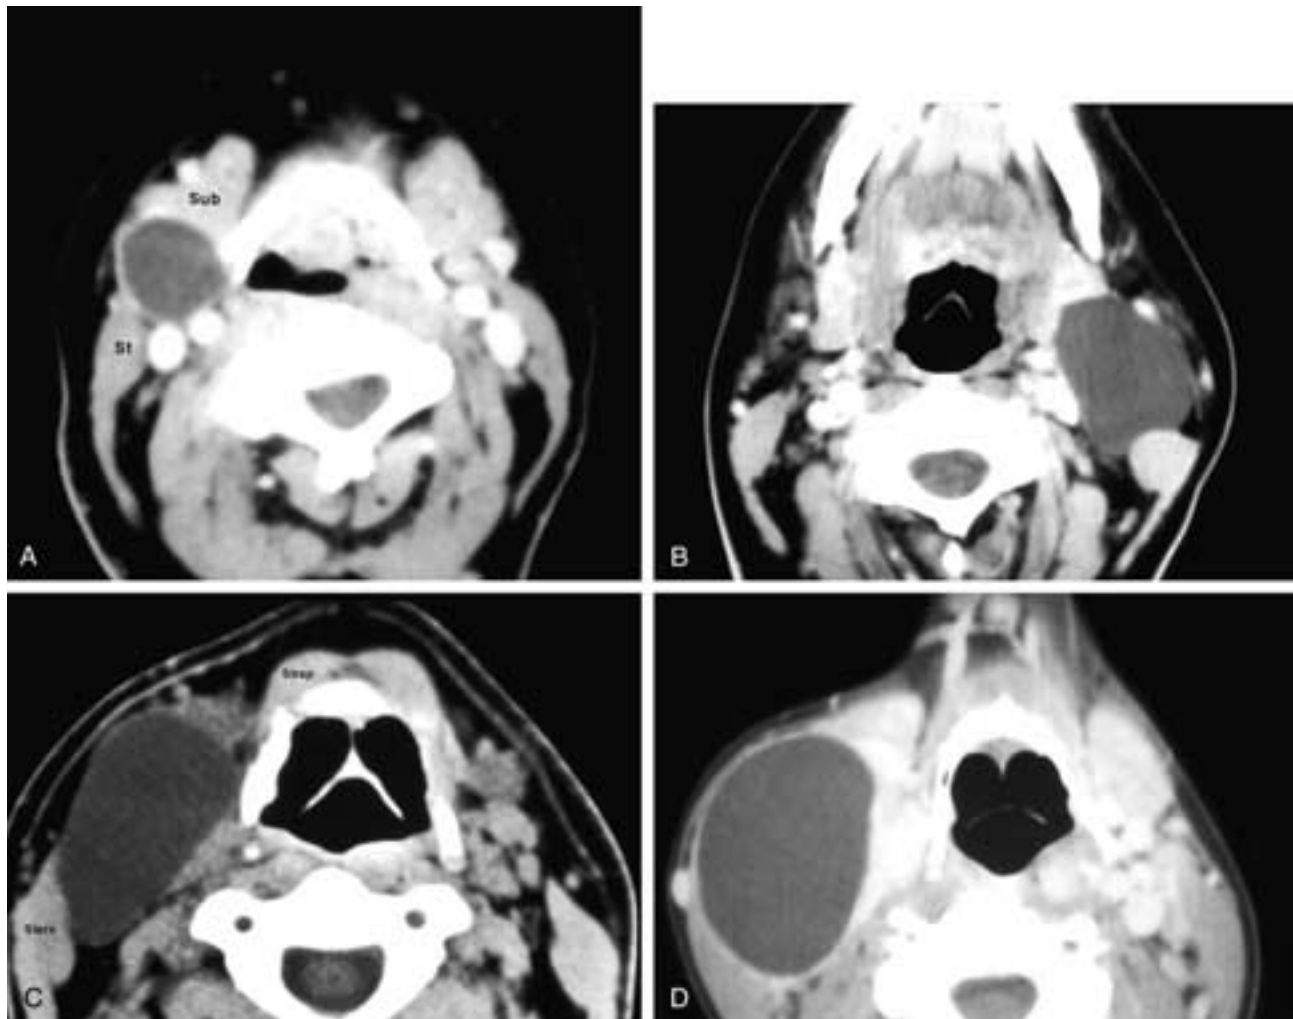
A, Axial contrast-enhanced CT scan shows a uniformly thin-walled right neck cyst positioned lateral to the carotid sheath structures, behind the right submandibular gland (*Sub*), and along the anterior border of the sternocleidomastoid muscle (*St*). This second branchial cleft cyst was located just caudal to the angle of the mandible. B, Axial contrast-enhanced CT scan shows a left neck cyst just behind the submandibular gland, lateral to the carotid sheath structures, along the anterior border of the sternocleidomastoid muscle, at or just caudal to the level of the angle of the mandible. This was a first branchial cleft cyst. C, Axial CT scan shows a large right neck cyst behind the submandibular gland, lateral to the carotid sheath structures, and just caudal to the level of the angle of the mandible. As this second branchial cleft cyst enlarges, the unseen superficial layer of the deep cervical fascia (extending from the sternocleidomastoid muscle (*Stern*) to the strap muscles (*Strap*) puts pressure on the cyst and pushes it dorsally deep to the Stern muscle. D, Axial contrast-enhanced CT scan shows a huge right second branchial cleft cyst lateral to the carotid sheath structures, behind the submandibular gland, just caudal to the level of the angle of the mandible, and partially deep to the sternocleidomastoid muscle (see B).
